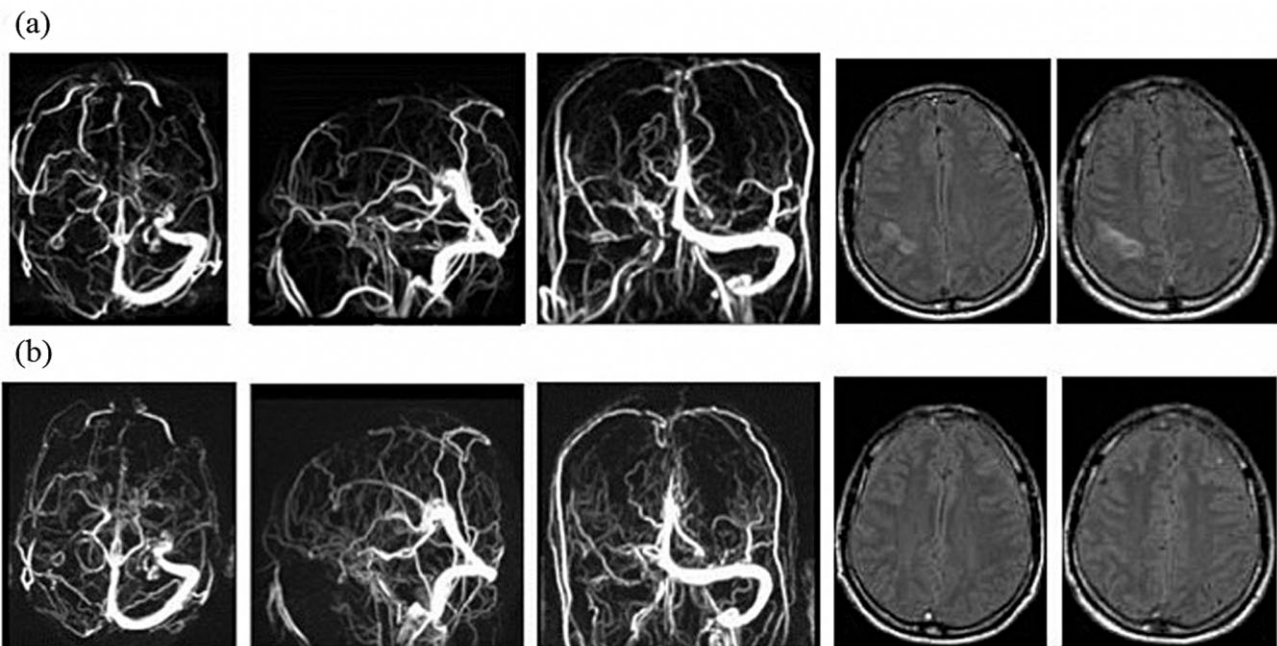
Figure revealing sigmoid sinus thrombosis extending to superior sagittal sinus and cortical veins coupled with the hyperintense lesion in the right parietal cortex evident in FLAIR sequences (a) with the development of many collateral veins and the disappearance of the hyperintense lesion after 10 days (b).
